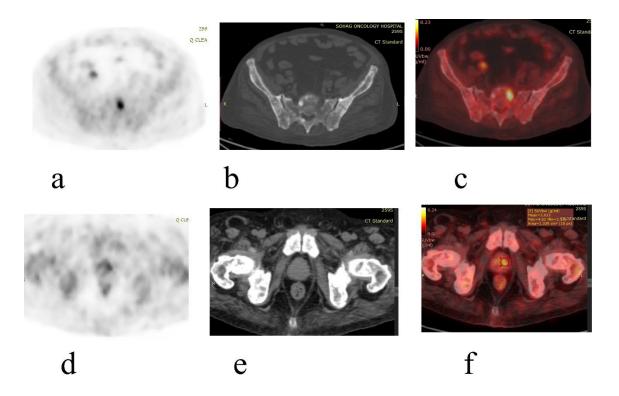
Case 2: axial views: a b& c images showing metabolically active sclerotic osseous metastatic lesions; a PET image, b CT image, c fused image, d, e& f images showing metabolically active prostatic lesion; d PET image, e CT image, f fused image
